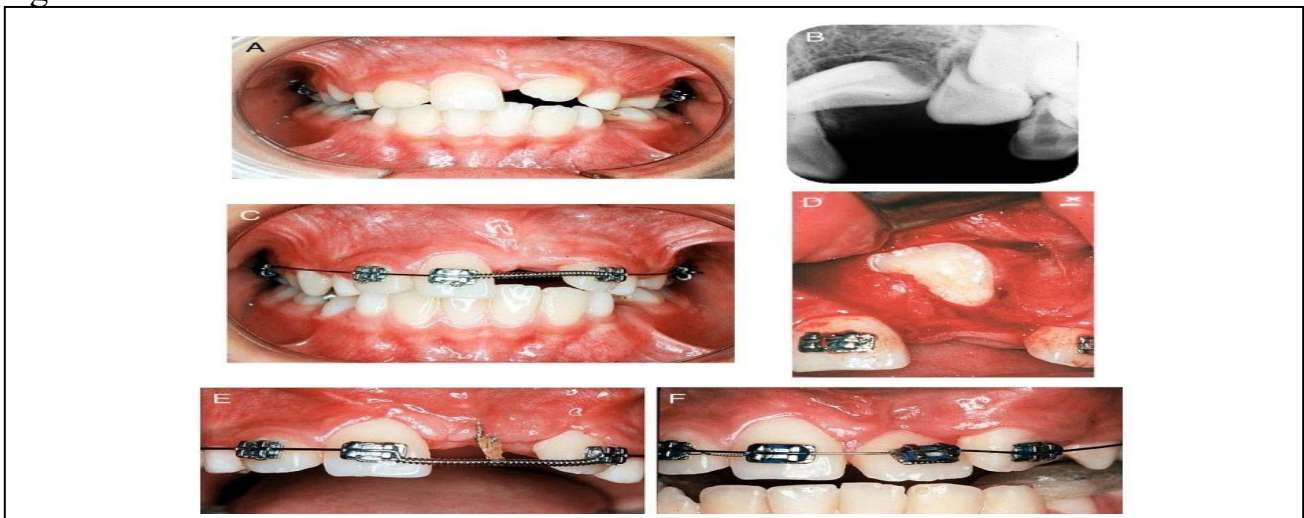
(A) Frontal view showing clinical absence of left maxillary central incisor with space closure and midline deviation; (B) pretreatment periapical radiograph; (C) compressed open-coil spring to open enough space for unerupted tooth; (D) surgical crown exposure showing its palatal surface; (E) elastic attached to alignment wire and hook end for initial movement; (F) left maxillary central incisor engaged in continuous arch wire showing improper tooth alignment due to divergent long axis (Jose´, 2010)
